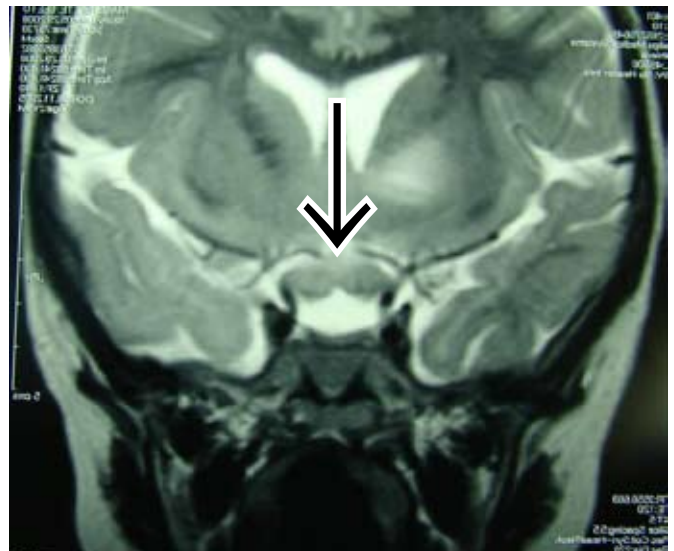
Coronal T2-weighted MRI demonstrates chiasmatic glioma in a patient with NF1. High signal is also visualised in the left basal ganglia.
